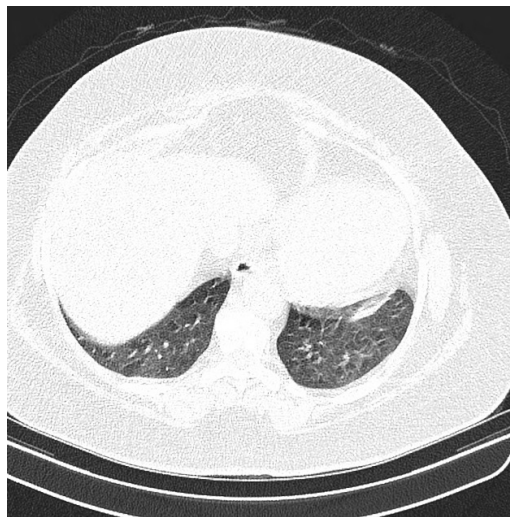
CT scan images showing the right-sided homogeneous opacity over the lower part of right lung and the herniated contents
